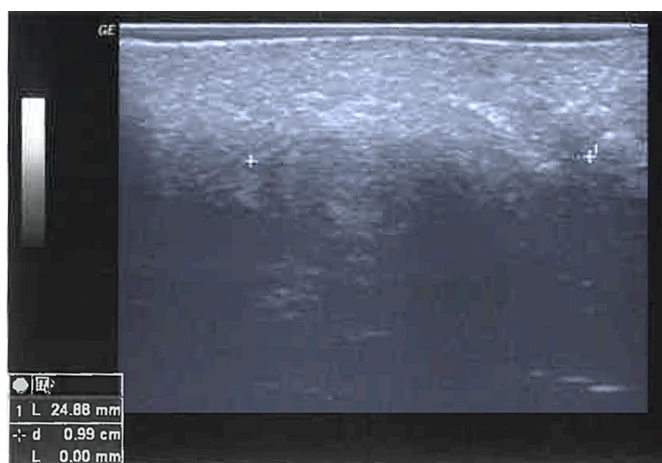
Sonographic findings showing a poorly circumscribed lesion without signs of a capsule.
